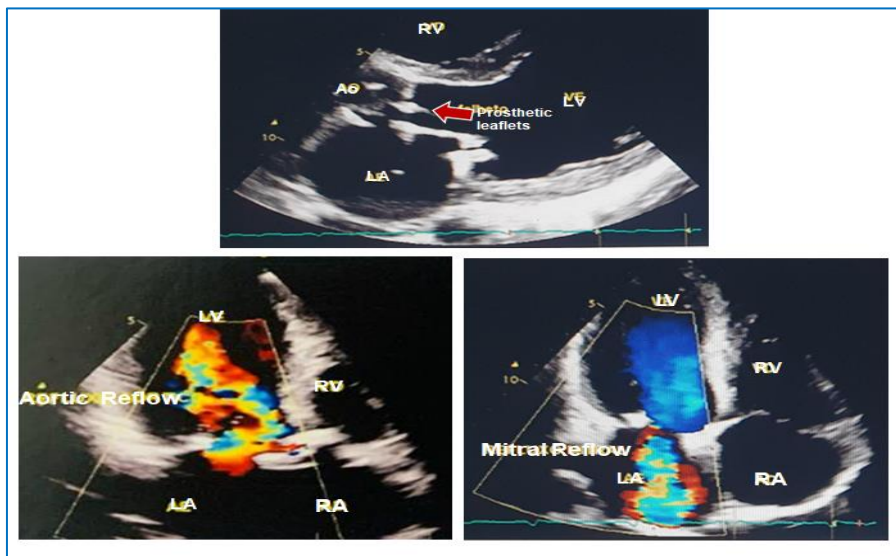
Doppler echocardiographic study: Important acute Aortic valve insufficiency (Prosthesis rupture) and moderate Mitral valve Insufficiency. (September 22, 2022).
